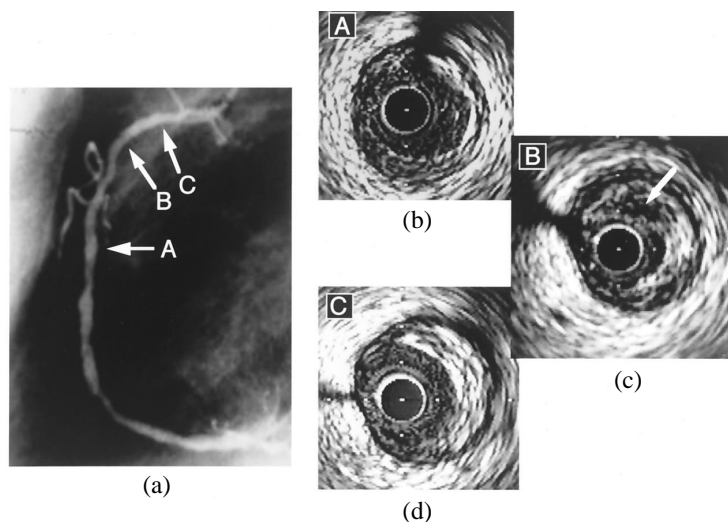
(a) Intravascular ultrasound (IVUS) image of a vulnerable atherosclerotic plaque of the RCA showing multiple luminal irregularities. (b) shows a mild concentric lesion at the distal portion at the location of A, (c) shows a significant eccentric lesion with 67% plaque area at the proximal portion at the location of B, and (d) shows an eccentric lesion at the very proximal portion at the location of C (Yamagishi et al. 2000).
